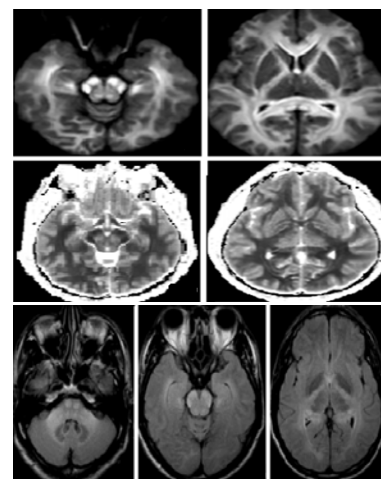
Brain MRI shows diffuse bilateral symmetric high signal intensities in white matter including the brain stem, cerebellar peduncle, internal capsule, corpus callosum on diffusion-weighted images (DWI) (1-A,B) and low signal intensities on the apparent diffusion coefficient map (1-C,D). Fluid-attenuated inversion recovery (FLAIR) (2-A, B, C) demonstrates high signal intensities in the same areas.
